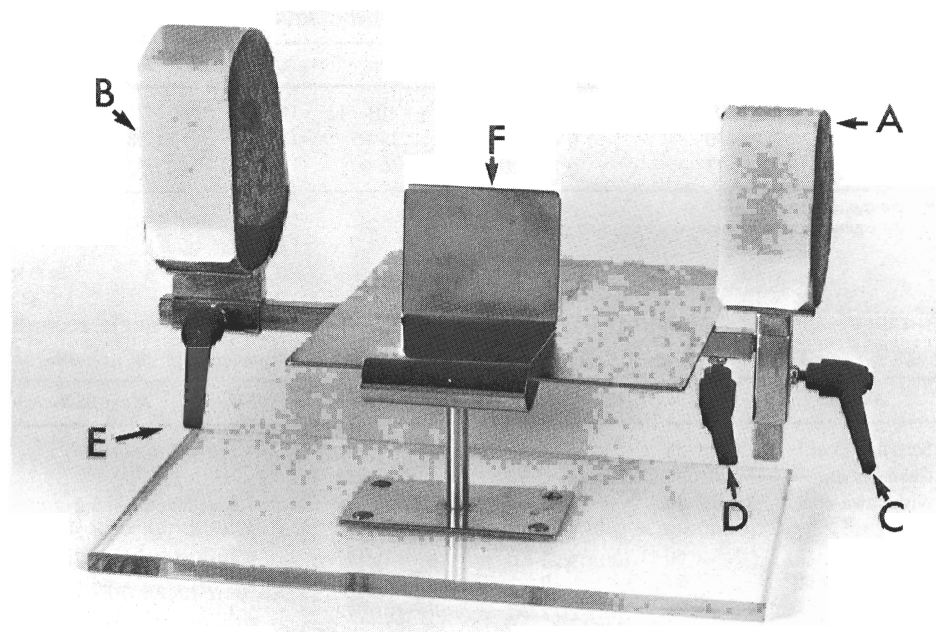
The stabilizing device. *A*, Finger support (changeable foam rubber shell, which can be adjusted to the size of the hand); *B*, forearm support (changeable foam rubber shell, which can be adjusted to the size of the forearm); *C*, height-adjustment screw; *D*, angulation-adjustment screw; *E*, length-adjustment screw; *F*, cassette support. (From Larsen CF, Stigsby B, Mathiesen FK, Lindequist S. Radiographic examination of the wrist. *Acta Radiol* 1990;31(5).
